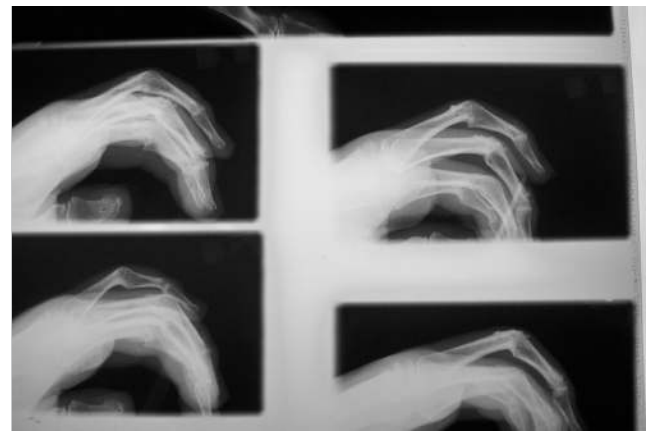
Radiographic evidence of solid proximal interphalangeal (PIP) joint arthrodesis 8 weeks postoperatively.
